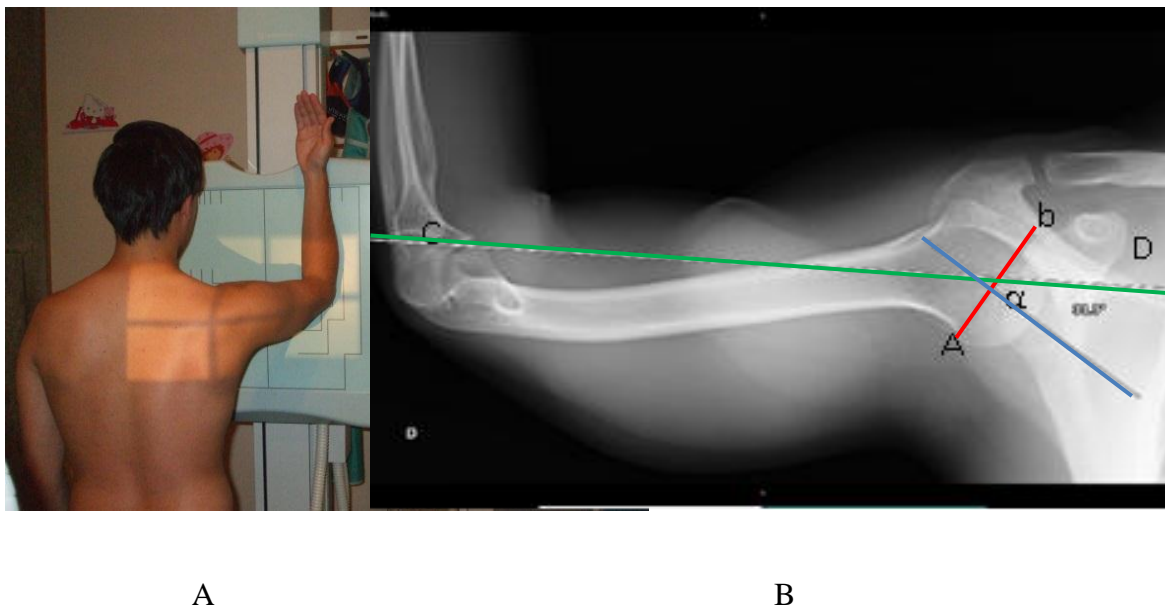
Semi-axial radiograph positioning (A) with references used on humeral retroversion angle calculation (B)
